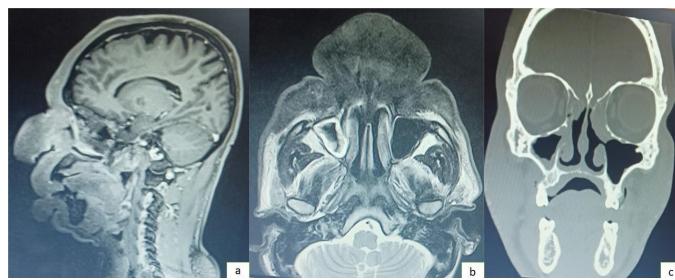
(a, b) Magnetic resonance imaging of face shows diffuse T2 hypointense soft tissue thickening in frontal, nasal and maxillary regions bilaterally; (c) Computed tomography of the osteo-meatal complex showing mucosal thickening seen in right maxillary and bilateral ethmoid sinus, nasal septum with hypertrophy of nasal turbinates.
